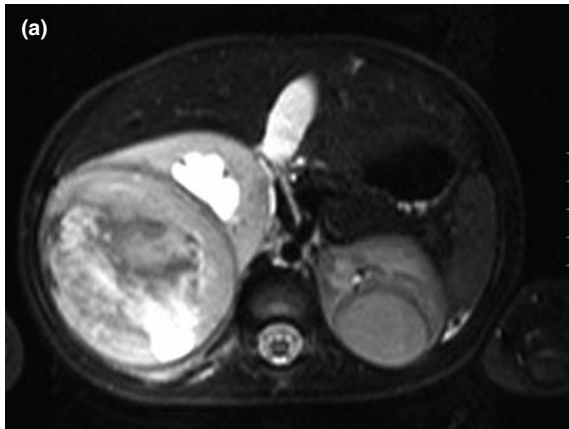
Wilms' tumour. (a) MRI with intravenous contrast in the transverse plane shows bilateral Wilms' tumour in a horseshoe kidney. (b) DMSA in the same patient showing the bilateral tumours as photopenic areas since they do not contain normally functioning renal tissue.
